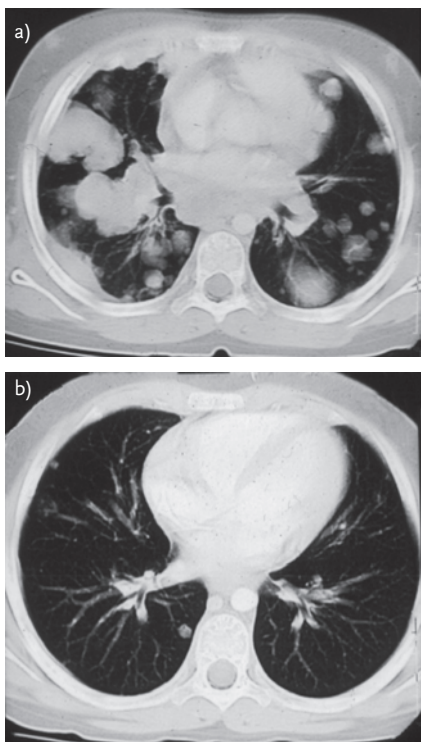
Metastatic Wilms tumour in a 9-year-old girl. a) A chest axial CT scan showing bilateral, large, hilar nodes and multiple round lung lesions with right pleural thickening. b) A chest axial CT scan performed after chemotherapy showing a dramatic decrease in parenchyma lesions and hilar nodes. There is no pleural involvement.
